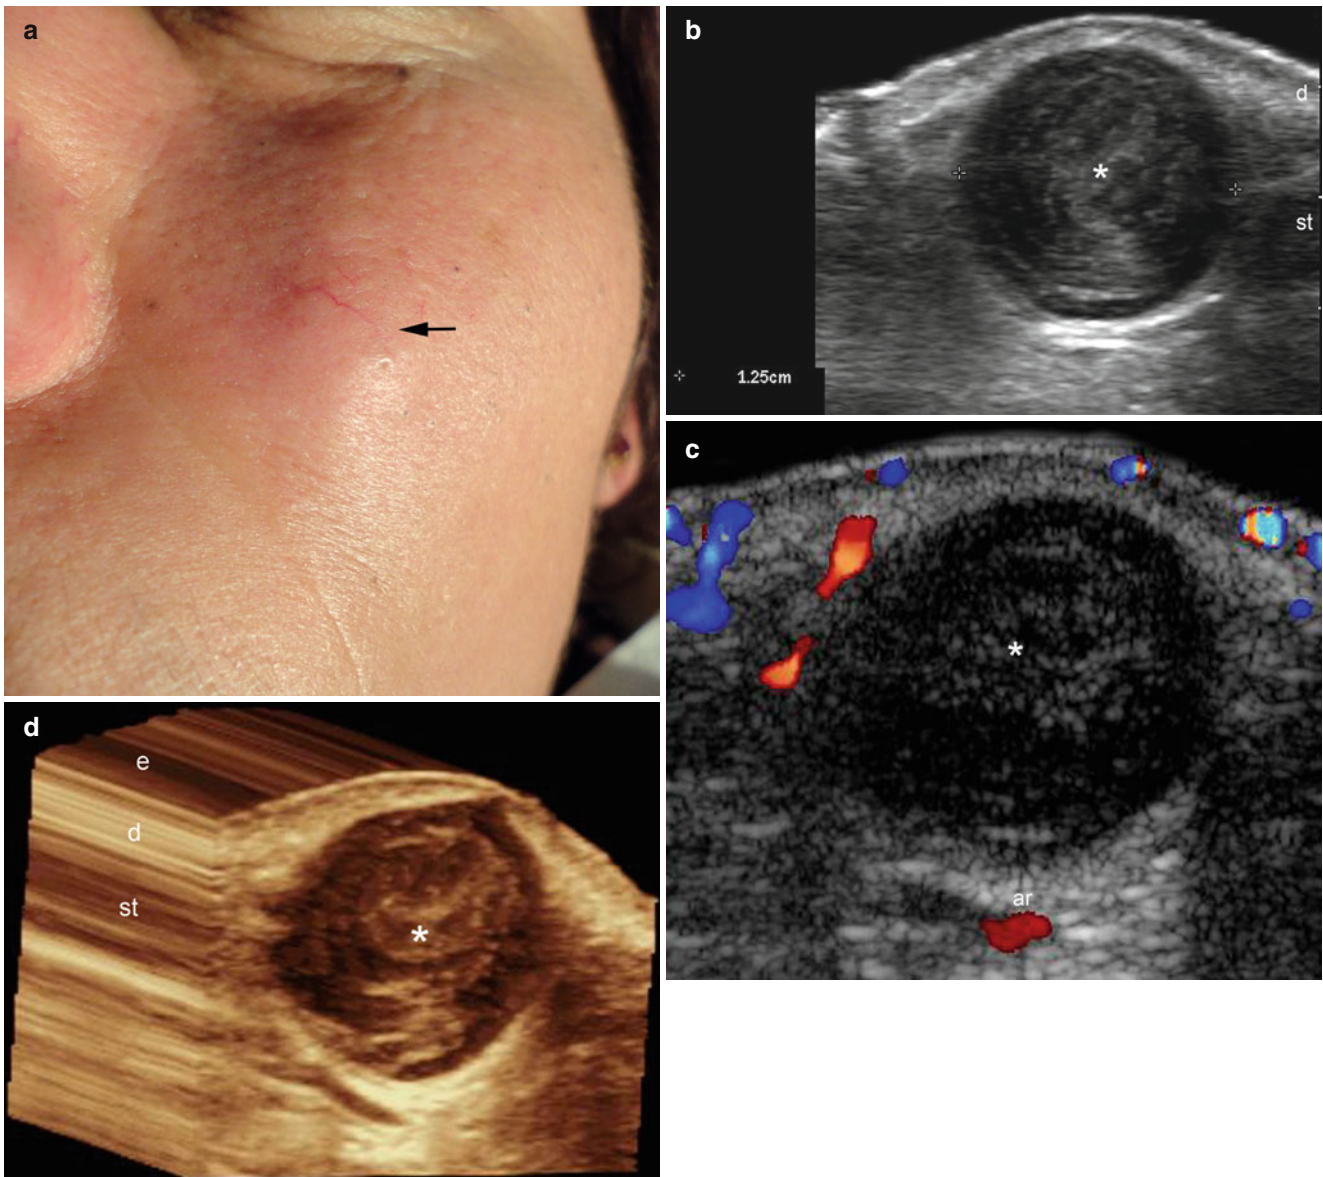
(a–d) Inflamed epidermal cyst. (a) Clinical erythematous swelling in the left cheek. (b) Grey scale ultrasound image (transverse view) demonstrates a 1.25 cm well-defined round shaped hypochoic structure (*) located in dermis and subcutaneous tissue. (c) Color Doppler ultrasound image (transverse view) shows increased blood
